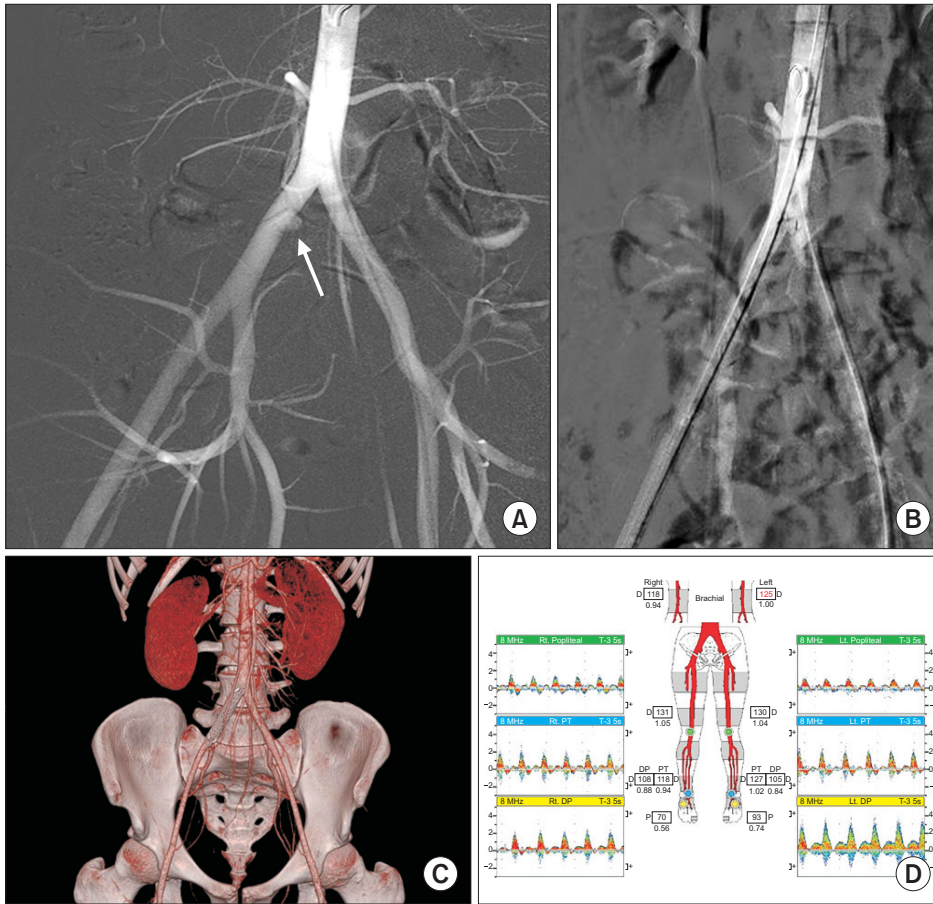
(A) Two weeks after discectomy, angiography shows pseudoaneurysm of the right common iliac artery (CIA) (arrow). (B) Covered stent deployment was performed. (C) One week after intervention, computed tomography angiogram shows successful exclusion of pseudoaneurysm of right CIA. (D) 10 days after intervention, follow-up vascular lab shows no abnormal finding. PT, posterior tibial; DP, dorsalis pedis.
